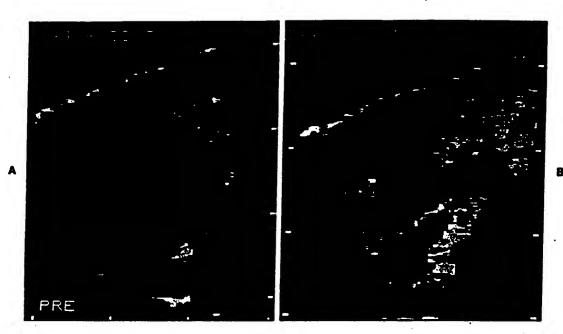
Cortical color Doppler enhancement improves the delineation of a renal mass. A, Color Doppler preinjection image through the upper pole of the right kidney in a rabbit with an implanted VX2 tumor shows a slight cortical bulge and loss of the normal cortical medullary distinction (arrows). B, Following 0.3 ml/kg of Albunex, dense color Doppler enhancement of the normal renal cortex occurs. The hypovascular mass does not enhance, improving detectability of the mass.
